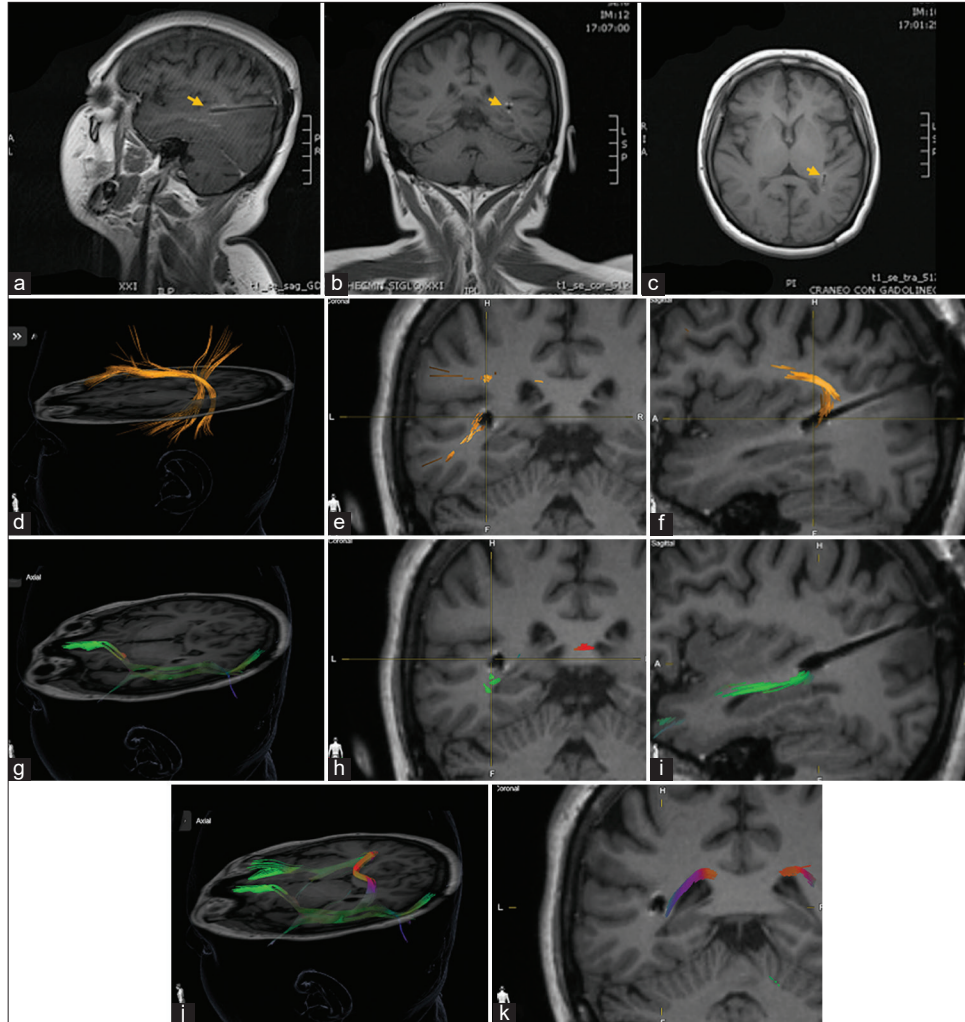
(a-i) Postoperative magnetic resonance imaging electrode localization and diffuse tensor imaging (DTI) tractographic reconstruction of Posterior Sylvian Junction (PSJ) (yellow arrow figures a/b/c). (d/e/f) Arcuate-Superior Longitudinal Fascicle (*in orange*) complex diffusion tensor imaging in axial, coronal, and sagittal view demonstrates the medial position of the electrode in relation to the superficial layer of the PSJ at this level. (g/h/i/j) Inferior Frontal Occipital Fascicle (IFOF) (*in green*) DTI located in the deep sagittal stratum layer of the PSJ. The electrode is visualized in this layer. (h/j/k) The Tapetum (*in red and purple*) is identified in the deep layer of the PSJ, medial to the electrode.
